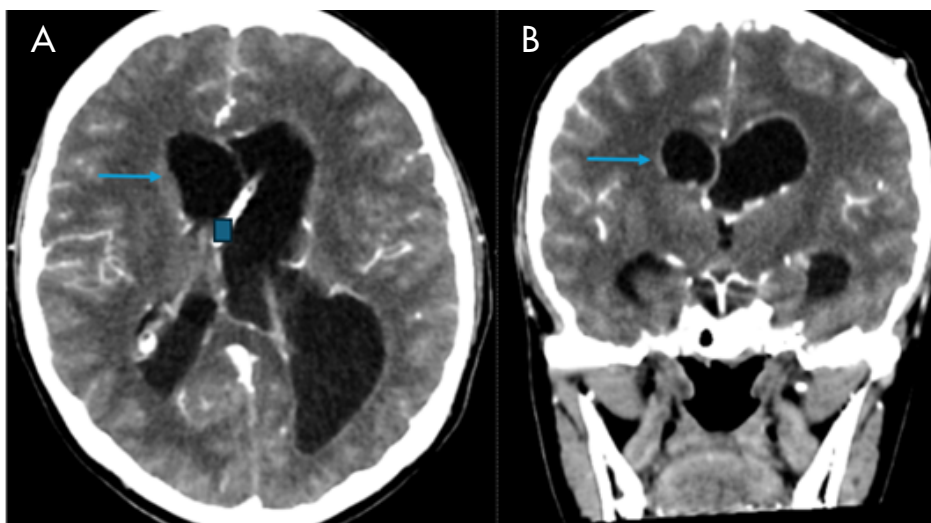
Contrast-enhanced computed tomography scan of the skull (A: axial view; B: coronal view) showing ependymal enhancement after contrast administration (arrow) and the distal end of the external ventricular drain catheter positioned in the right lateral ventricle (box).
